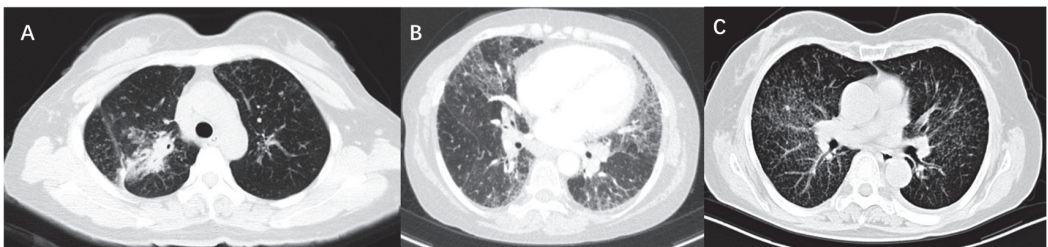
CT images of three patients with sarcoidosis. (A) Shows consolidation on CT scan and the PFT is characterized by restrictive ventilation dysfunction, with an FVC of 67.9% predicted and FEV1 of 61% predicted. (B) Shows fibrosis and bronchial distortion on CT scan and the PFT is characterized by restrictive ventilation dysfunction and decreased diffusion function, with an FVC of 44.4% predicted, FEV1 of 52.0% predicted, and DLCO of 50.9% predicted. (C) Shows multiple micronodules on CT scan and the PFT is characterized by mixed ventilation dysfunction, with an FVC of 71.3% predicted, FEV1 of 62.3% predicted, FEV1/FVC of 69.46%, and normal DLCO.
